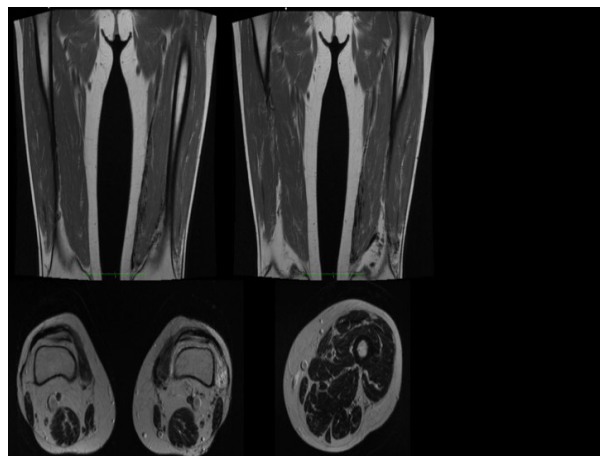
An MRI that confirmed the presence of air and exclude the infection.
